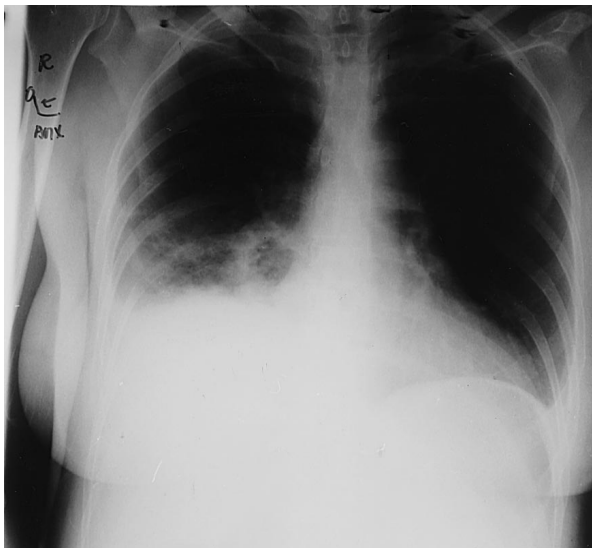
Chest radiograph showing pulmonary infiltrates in the right and middle lobe
